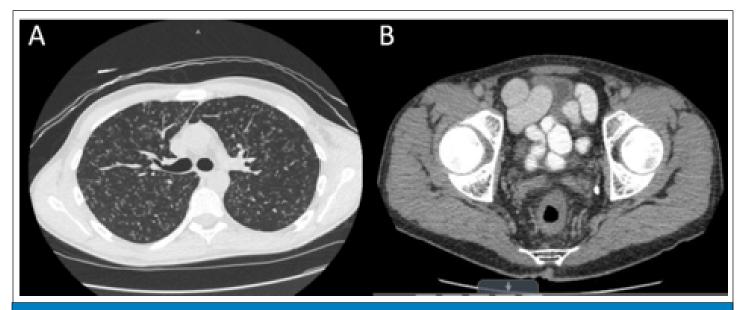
Axial Computerized Tomography (CT) Imaging. CT Chest non-contrast. Window Level = 550. Innumerable small pulmonary nodules (A) and Abdomen & Pelvis enterography with contrast. Window level = 40. Circumferential wall thickening with mild peri-colonic inflammation (B).
